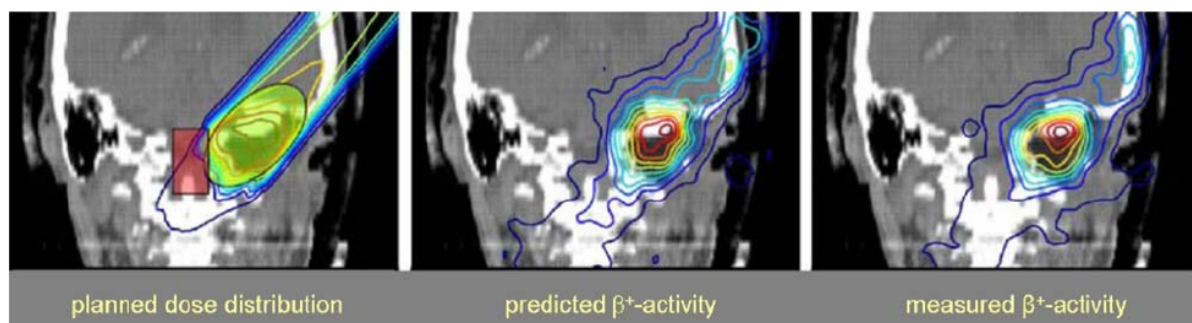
Example of in-beam PET monitoring showing the irradiation of a skull base tumor at GSI. Left: Planned dose distribution superimposed on the CT image. The target volume and the brain stem as an OAR are highlighted. Middle: Predicted β^+ -activity distribution calculated from the treatment plan and time course of the irradiation. Right: Measured β^+ -activity distribution. By comparison with the prediction it was verified that the carbon ions were correctly stopped before the brain stem (Crespo et al. 2006).
